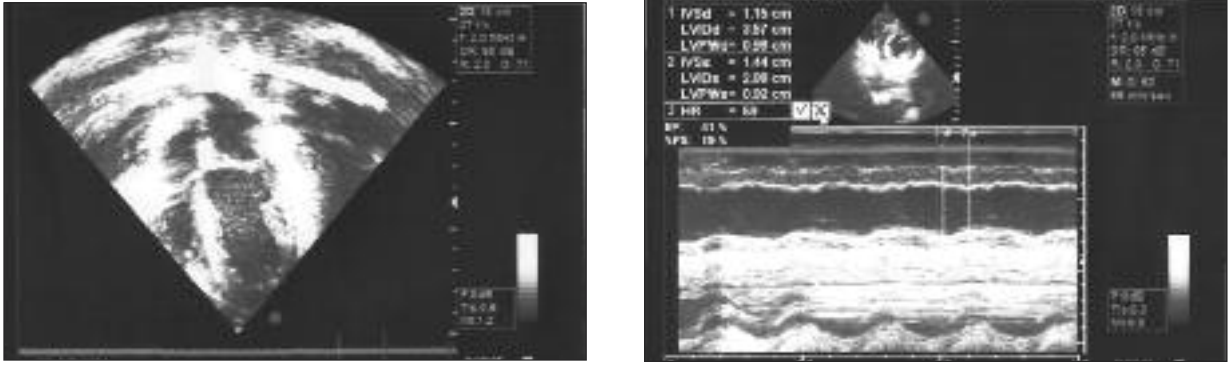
A) Spontaneous echo contrast appearance in the transthoracic echocardiographic examination. B) Systolic dysfunction in the M-Mode measurement.
